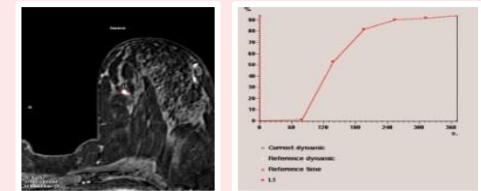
MRI with contrast and region of interest located (L1) – associated Type II curve
